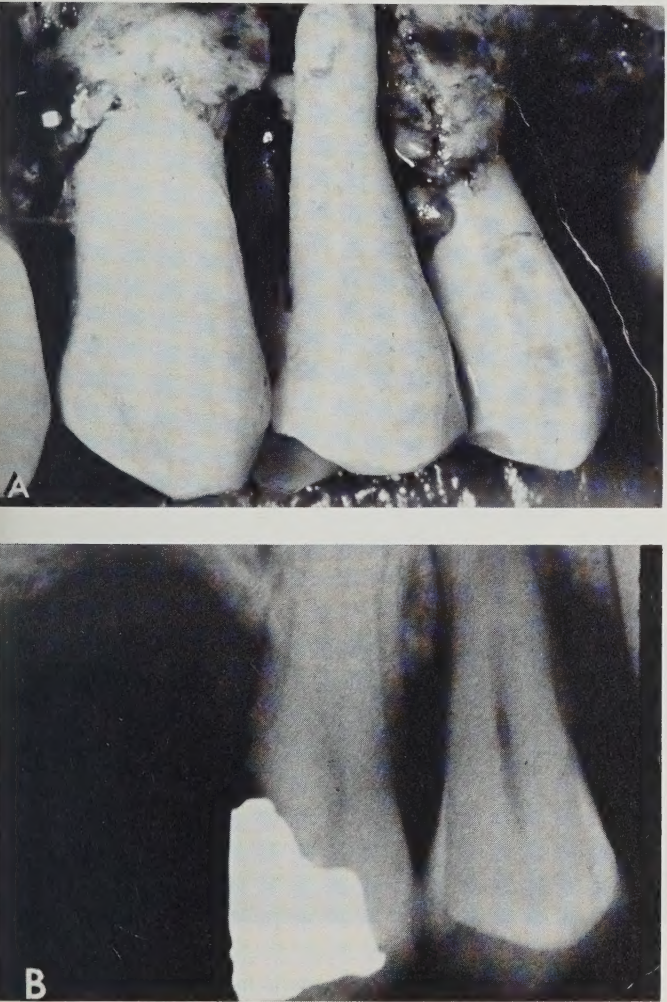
A. Dehiscence of buccal root of maxillary first bicuspid. B. Roentgenograph records evidence of extensive loss of marginal bone but no indication of the dehiscence or of periapical pathosis. The exposed apex can be identified by palpation during the clinical examination.†
